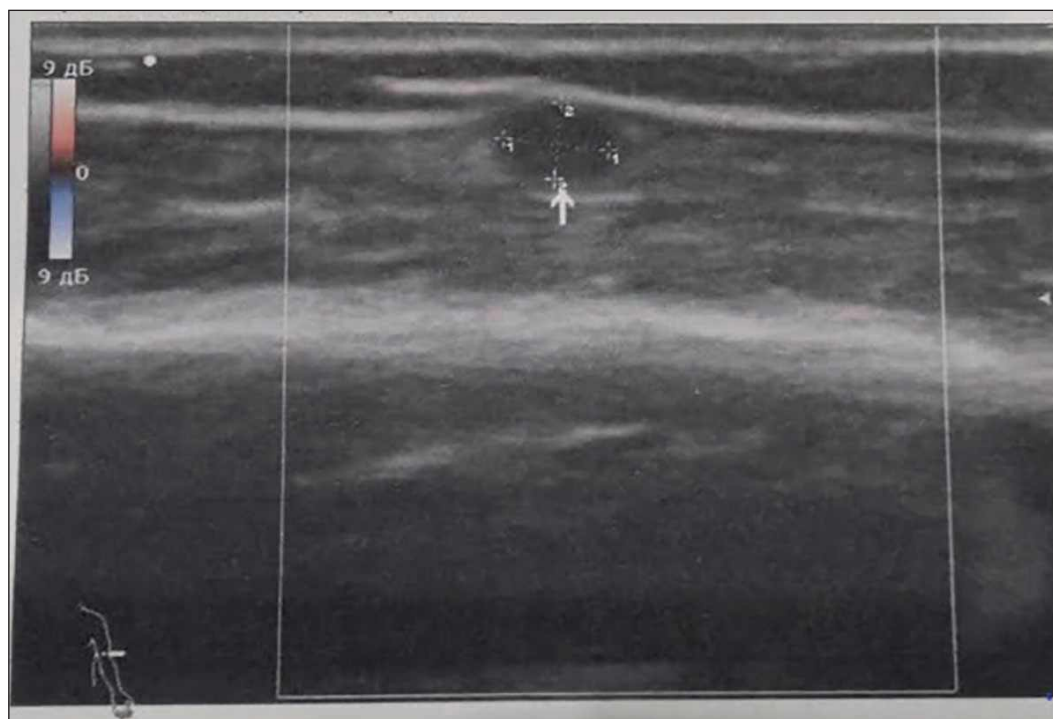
Ultrasound of shoulder neurilemmoma, showing a hypoechoic encapsulated formation
